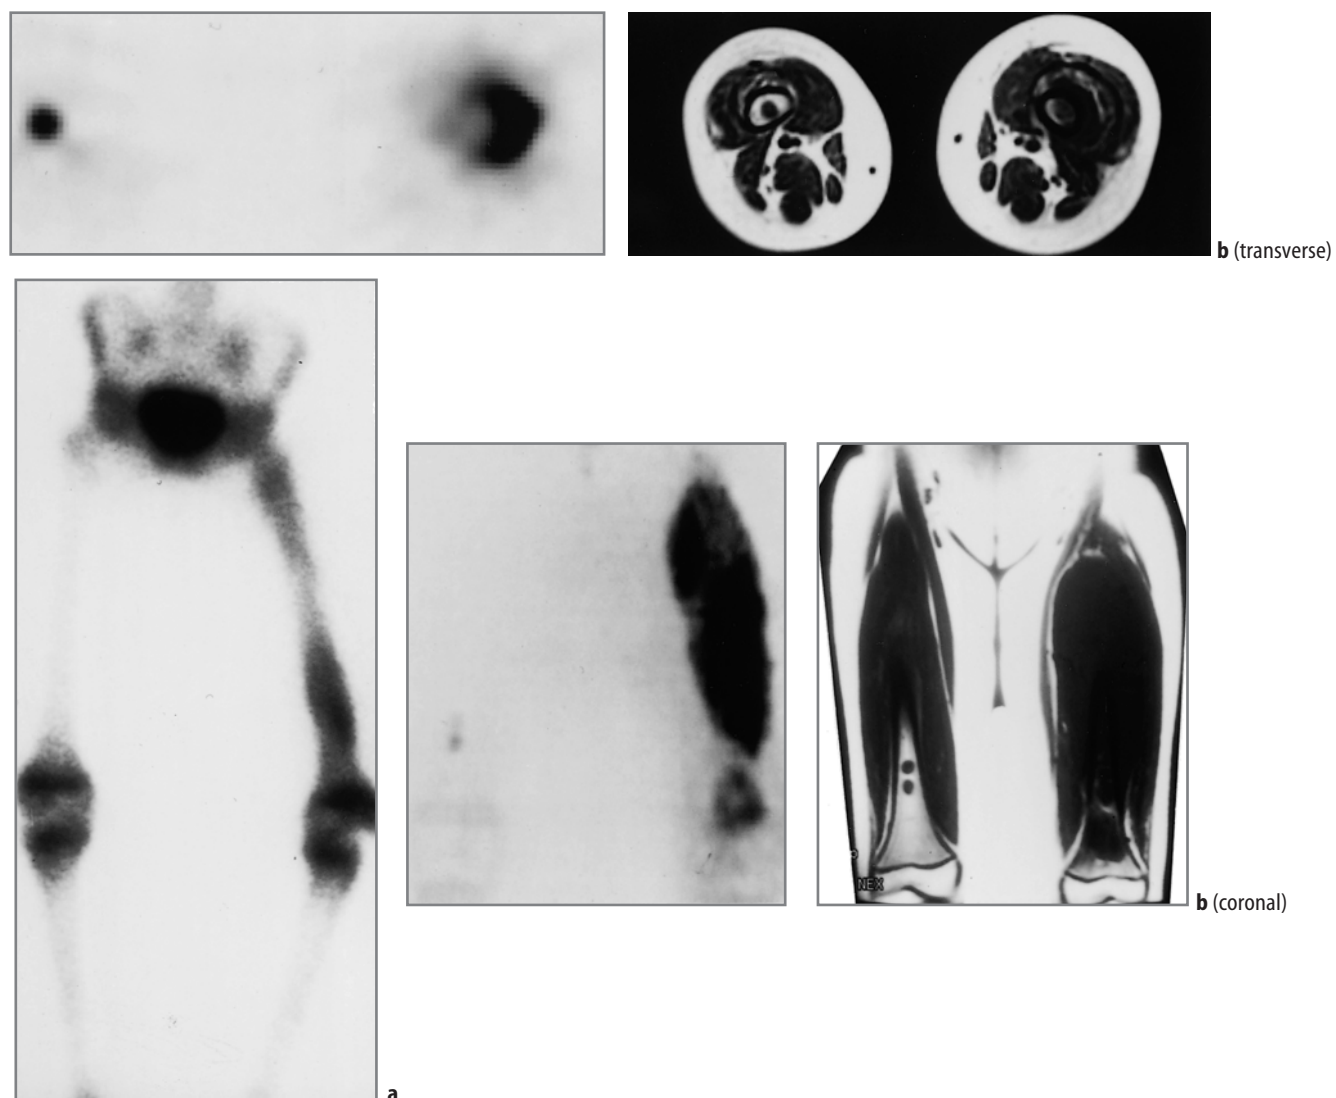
An 11-year-old girl who complained of pain and swelling in the left thigh. Plain film radiographs showed findings suggestive of Ewing's sarcoma, subsequently confirmed on biopsy. (a) Left panel: Bone scan obtained 2 h following injection of ^{99m}Tc -MDP. Abnormal accumulation of tracer is noted throughout the left femur. The right femur is unremarkable. Center panel: Anterior projection image from PET study shows intense, irregular uptake of FDG within the soft tissues of the left thigh. Two small foci of activity are seen in the region of the distal right femur that are not present on bone scanning. Right panel: T₁-weighted coronal MR image shows soft tissue mass in the left thigh, replacement of normal marrow of the left femur, and two focal lesions in the distal right femur. (b) Left panel: Transverse and coronal image from PET scan at the level of the distal femurs. Intense uptake of FDG is present in the soft tissues surrounding the left femur and focally within the right femur. Right panel: T₁-weighted MR image at same level shows the soft tissue mass surrounding the left femur, replacement of marrow of the left femur, and a lesion in the center of the right femur. (Reprinted with permission from Shulkin BL, Mitchell DS, Ungar DR, et al. Neoplasms in a pediatric population: 2-[F-18]-fluoro-2-deoxy-D-glucose PET studies. *Radiology* 1995;194:495–500.)
